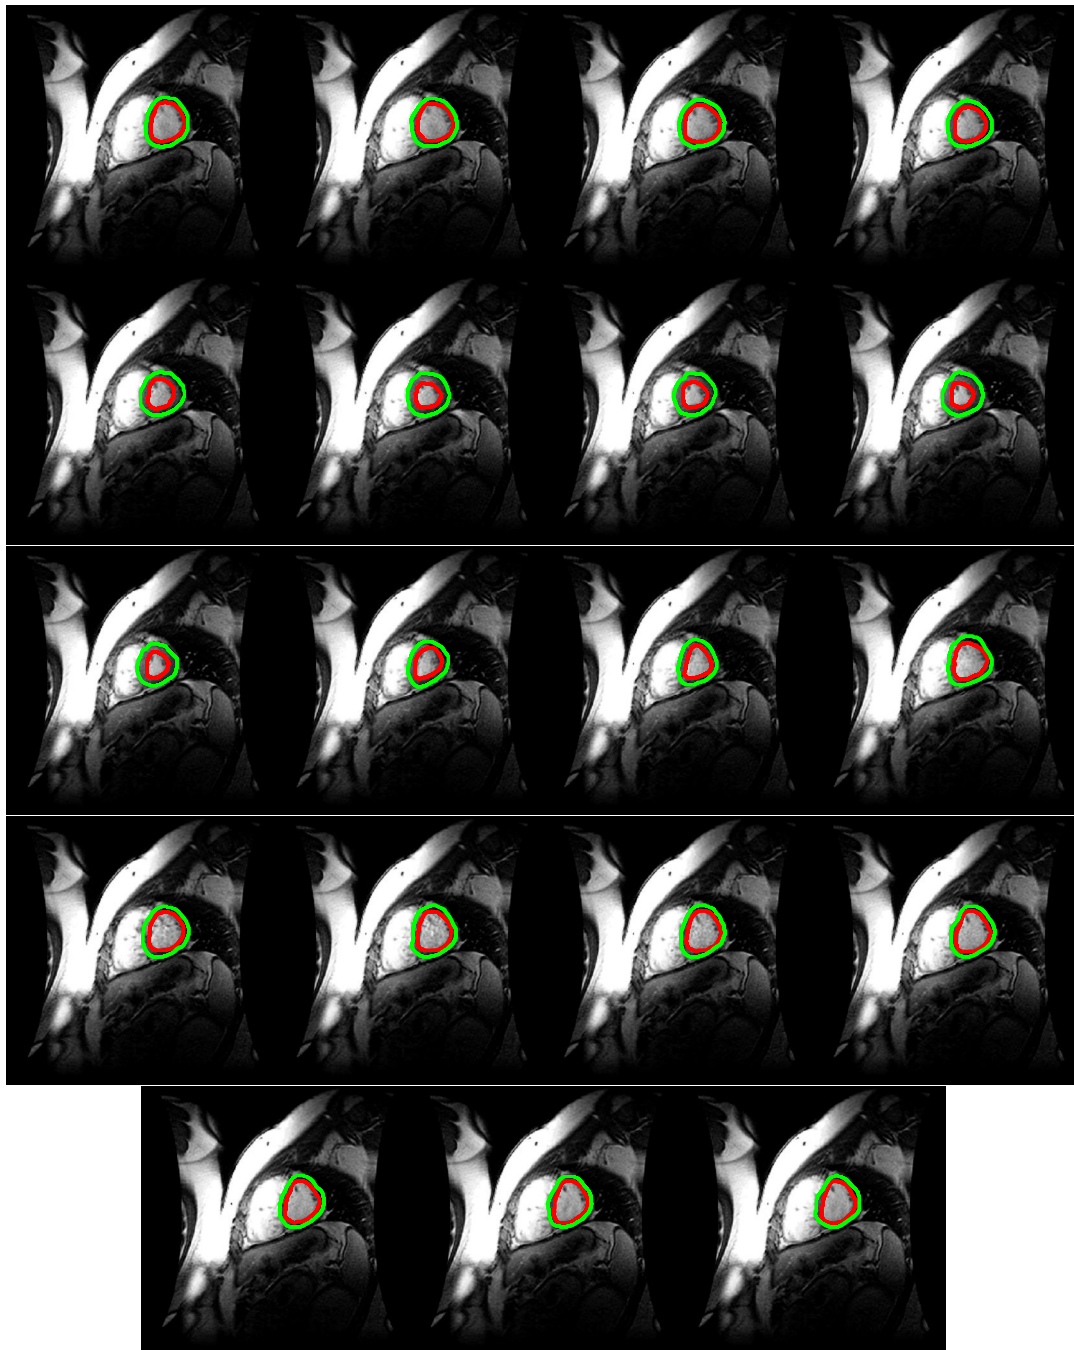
SAV MRI from YUD at for entire cardiac cycle for a patient with cardiac abnormality with segmentation performed on left ventricle endocardium (red contours) and epicardium (red contours)
